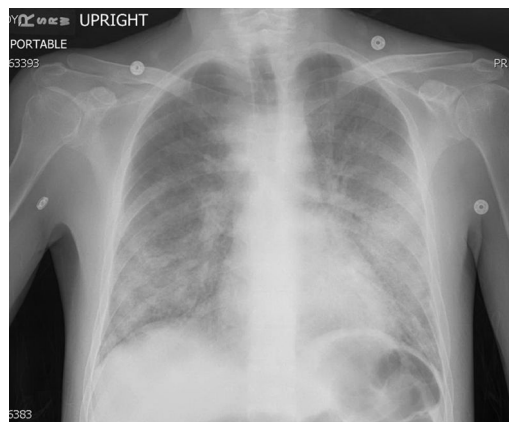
Chest X-ray demonstrating bilateral ground glass opacities.
